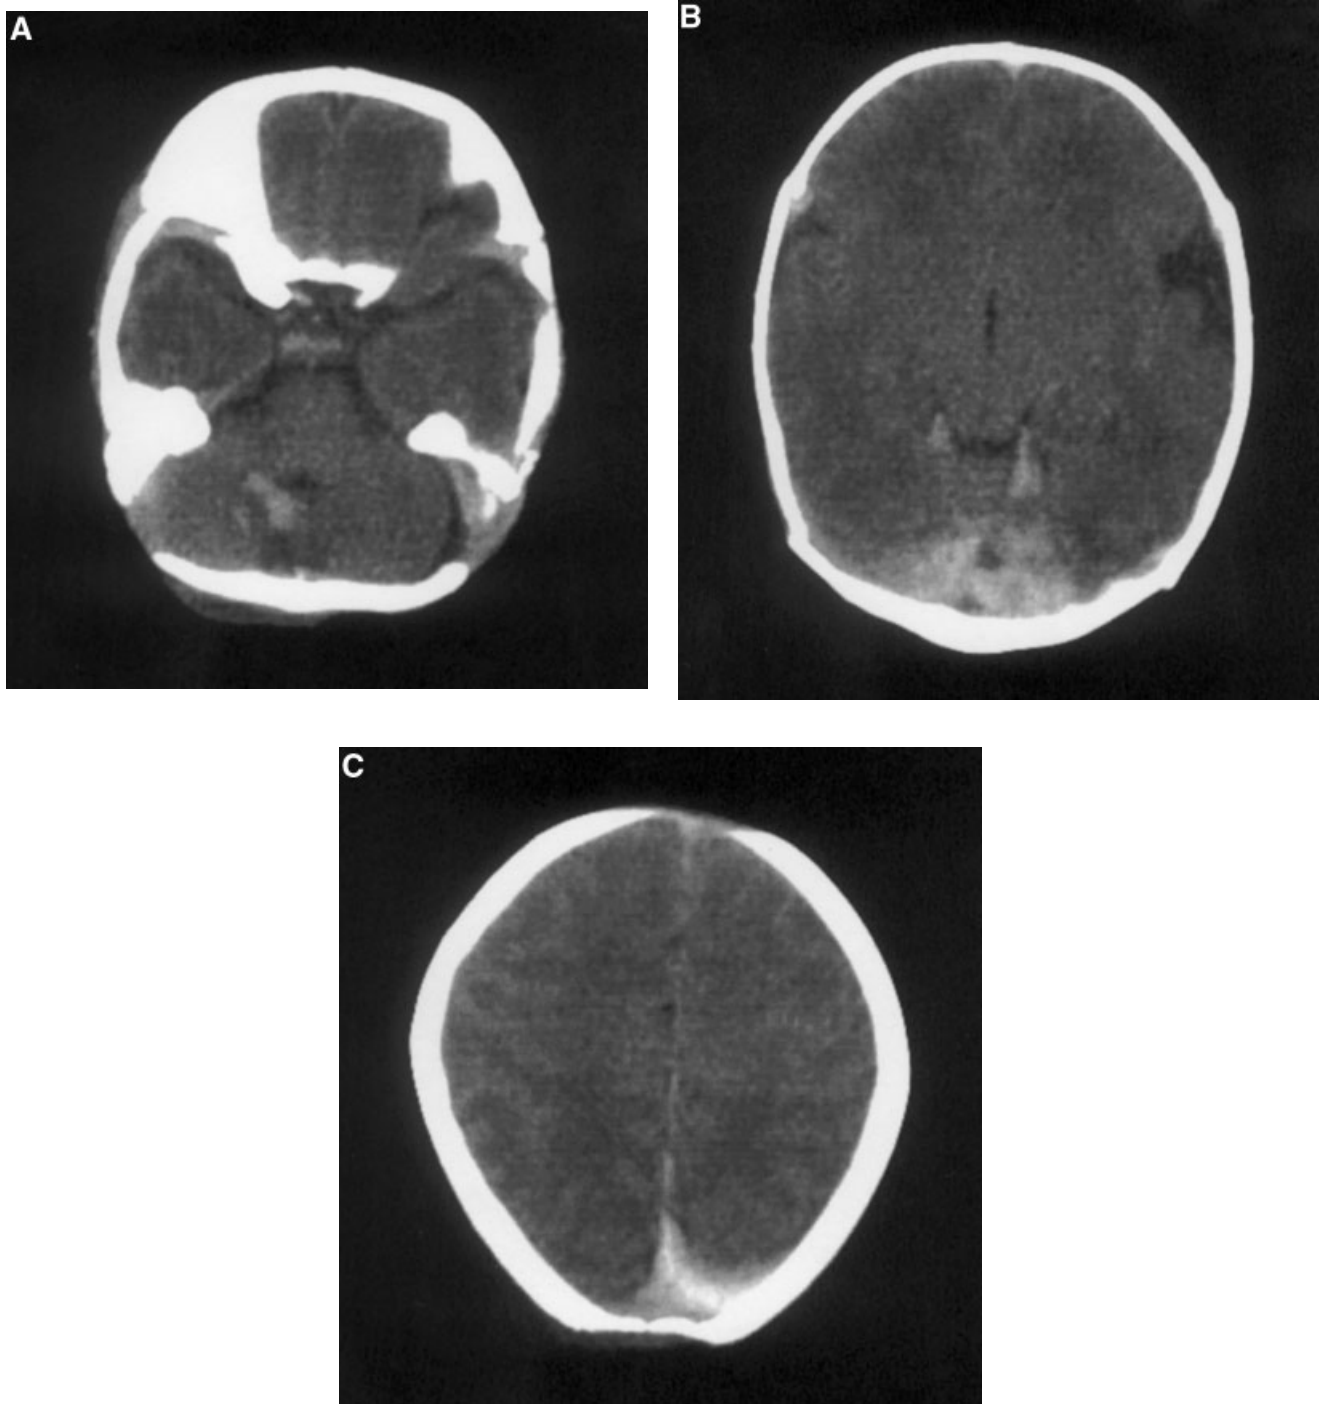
(Hospital Day 1). Computerized tomograph (CT) of the head without contrast done on admission. Subdural hemorrhage along the tentorium and interhemispheric fissure (A). Small foci of parenchymal hemorrhage are present in the periventricular region adjacent to the posterior body right lateral ventricle (B). Hemorrhage along the medial right cerebellum (C).
